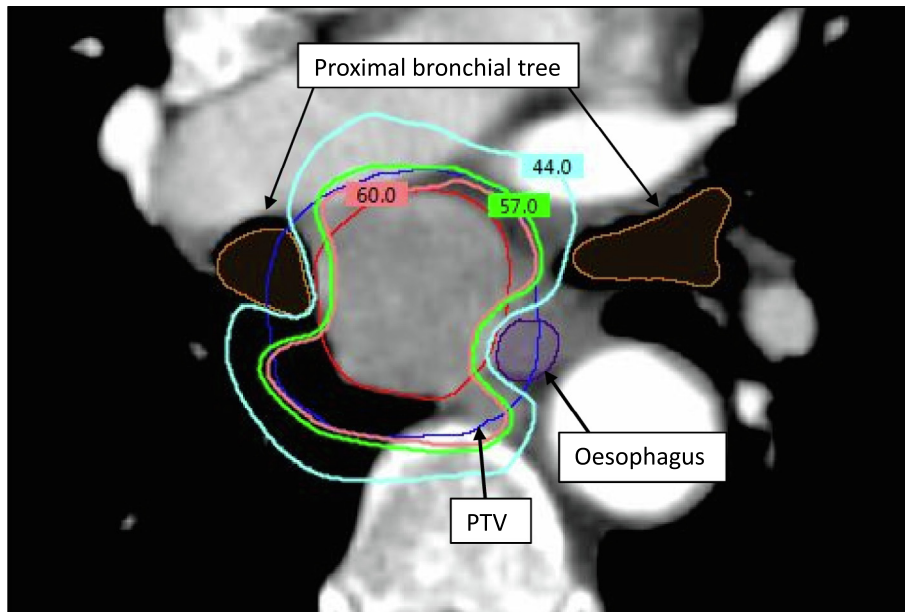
Axial image from planning CT for a case where PTV overlapped with proximal bronchial tree and oesophagus, requiring compromise to PTV dose coverage. Isodose lines represent absolute dose in Gray.
